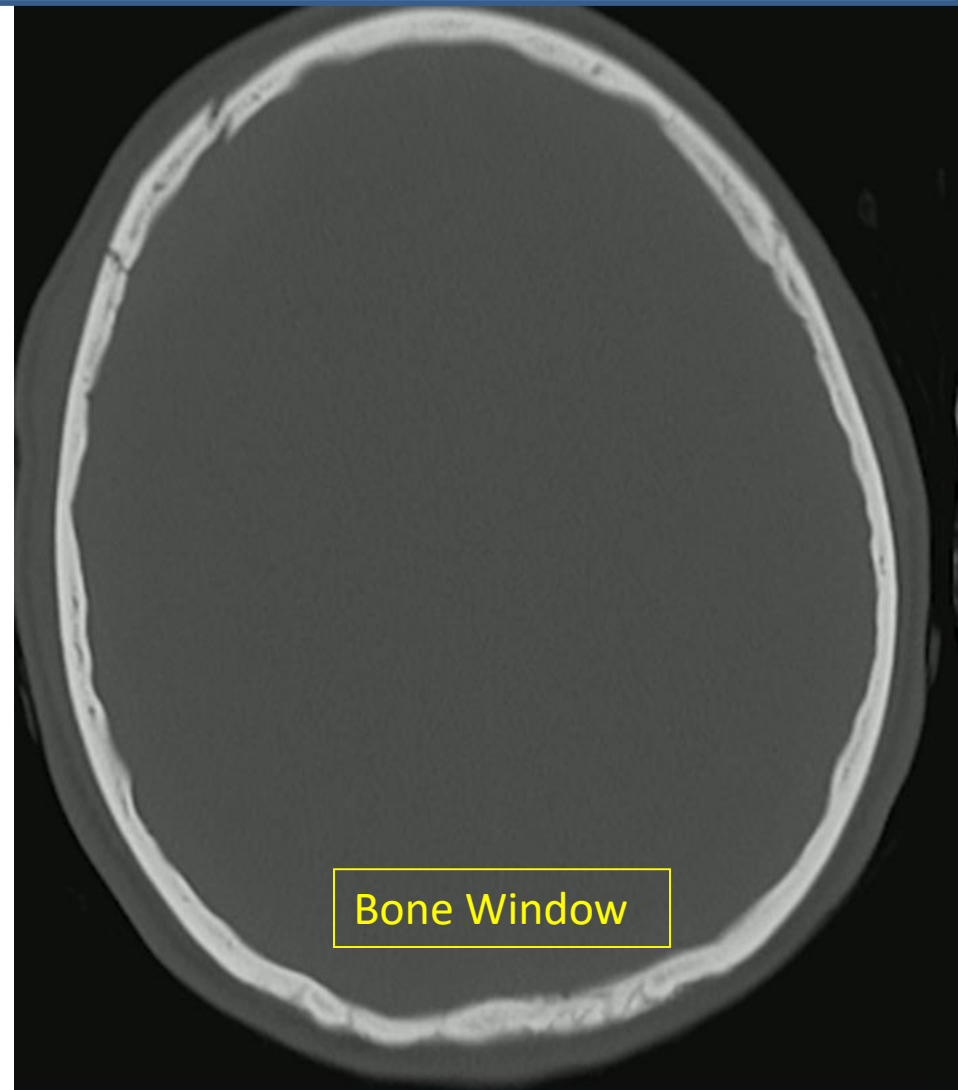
Depressed skull fracture in a 16-year-old boy struck by a golf ball. a Axial CT image using bone window settings shows depressed fracture in left frontal bone. b Unenhanced axial CT image at same level as a using soft tissue window settings shows hemorrhagic contusion subjacent to depressed skull fracture
